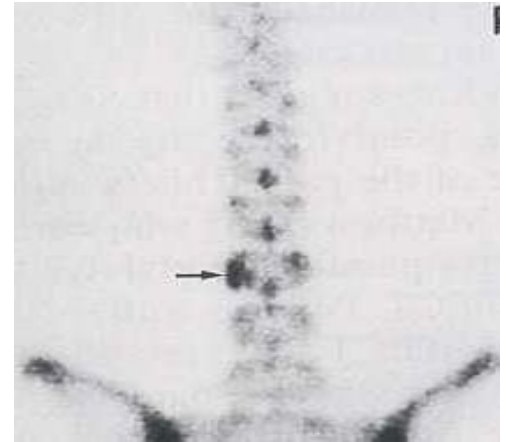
Bone SPECT Scan showing pars fracture [black arrow]
